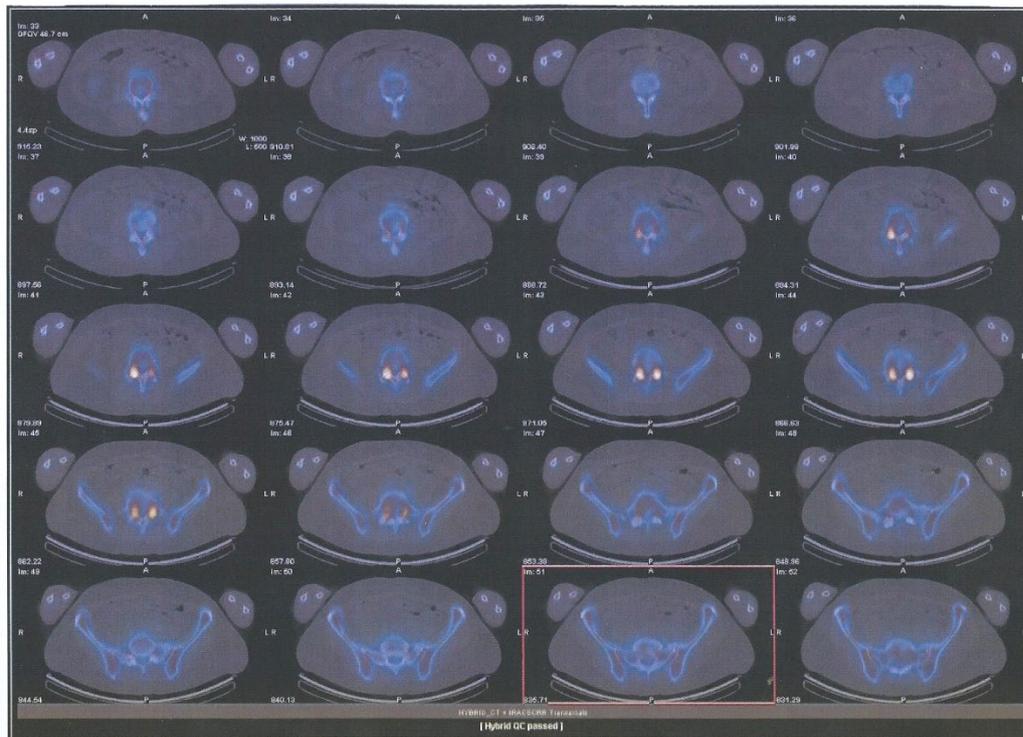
SPECT/CT scintigraphy displaying fused SPECT/CT transaxial slices of the L4-5 facet joint pathological uptake.
